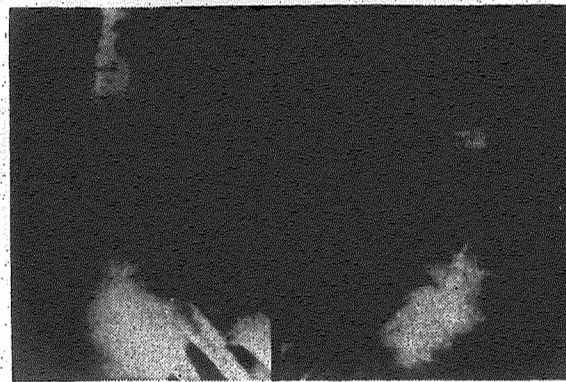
Roentgenograms of both fibulae of a 36-year-old man who first experienced pain in his right ankle while jogging. Running was terminated for 4 weeks but he did not seek medical advice. On resuming jogging he experienced pain in the left ankle. In October x-rays were taken of both ankles for the first time. The healed fatigue fracture of the right fibula is shown on the left. Pictured on the right is the healed fatigue fracture of the left fibula after 3 weeks of plaster immobilization. Note the difference in callus formation between the two fractures.
